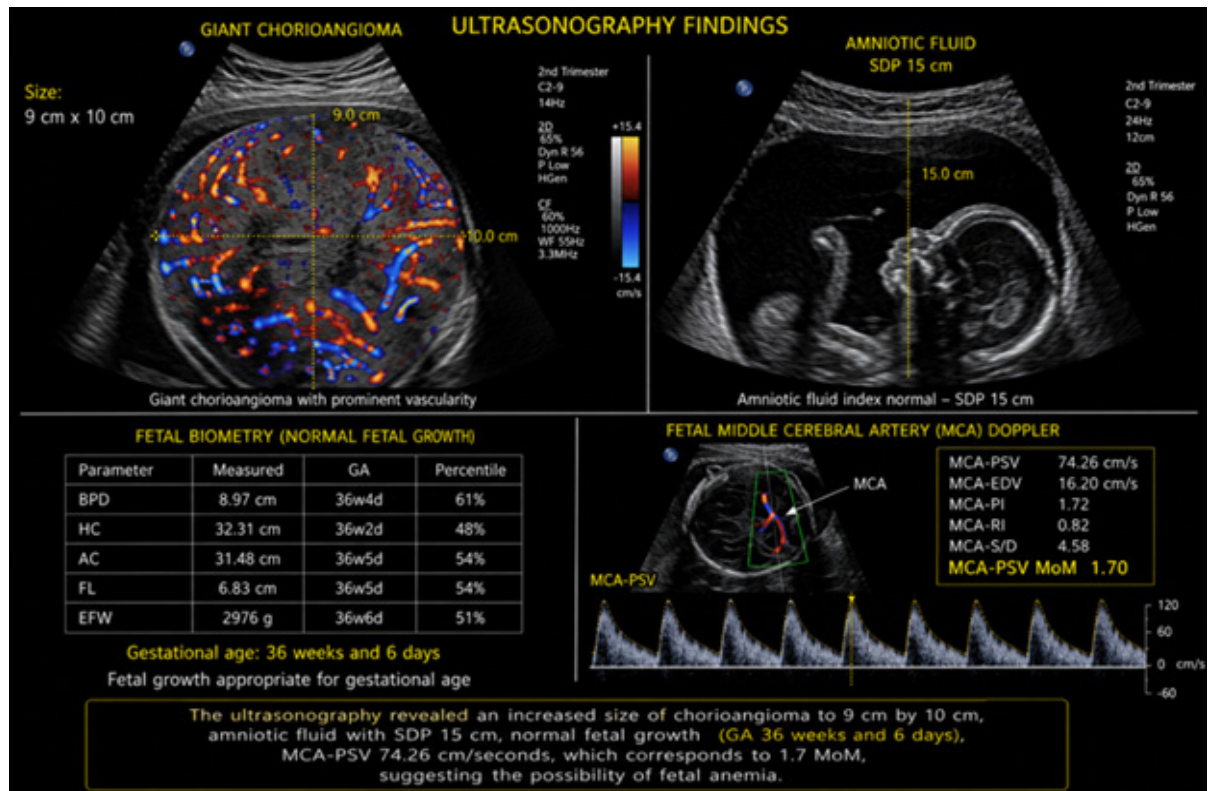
MCA-PSV/Color Doppler
